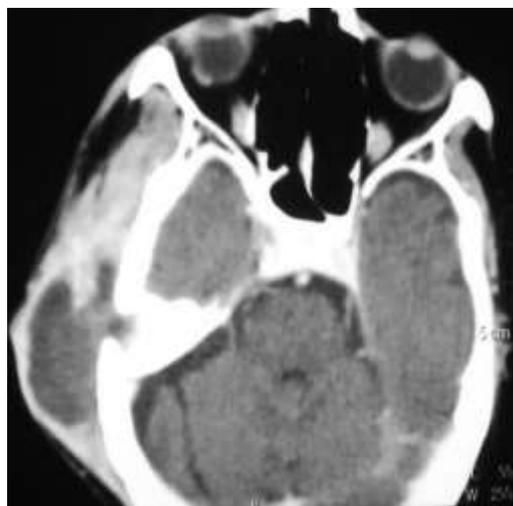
Right zygomatic abscess with CT brain showing zygomatic hyperdense collection
